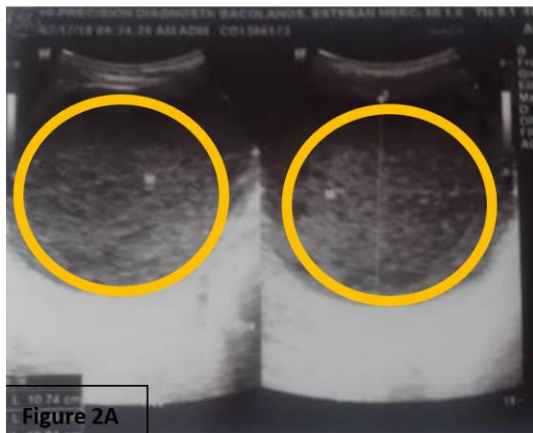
(Top) Admission ultrasound of the whole abdomen of the patient. Encircled in yellow is a 10.7cm x 9.2cm x 10.8cm thick-walled complex mass within the right lobe of the liver with echogenic debris signifying a liver abscess. (Bottom) Repeat ultrasound of the whole abdomen a month after liver abscess aspiration and intensive quadruple anti-tuberculous therapy. The liver is not enlarged with a homogenous parenchymal echo pattern. No parenchymal cystic or nor solid masses were demonstrated. There is a complete resolution of liver abscess.
